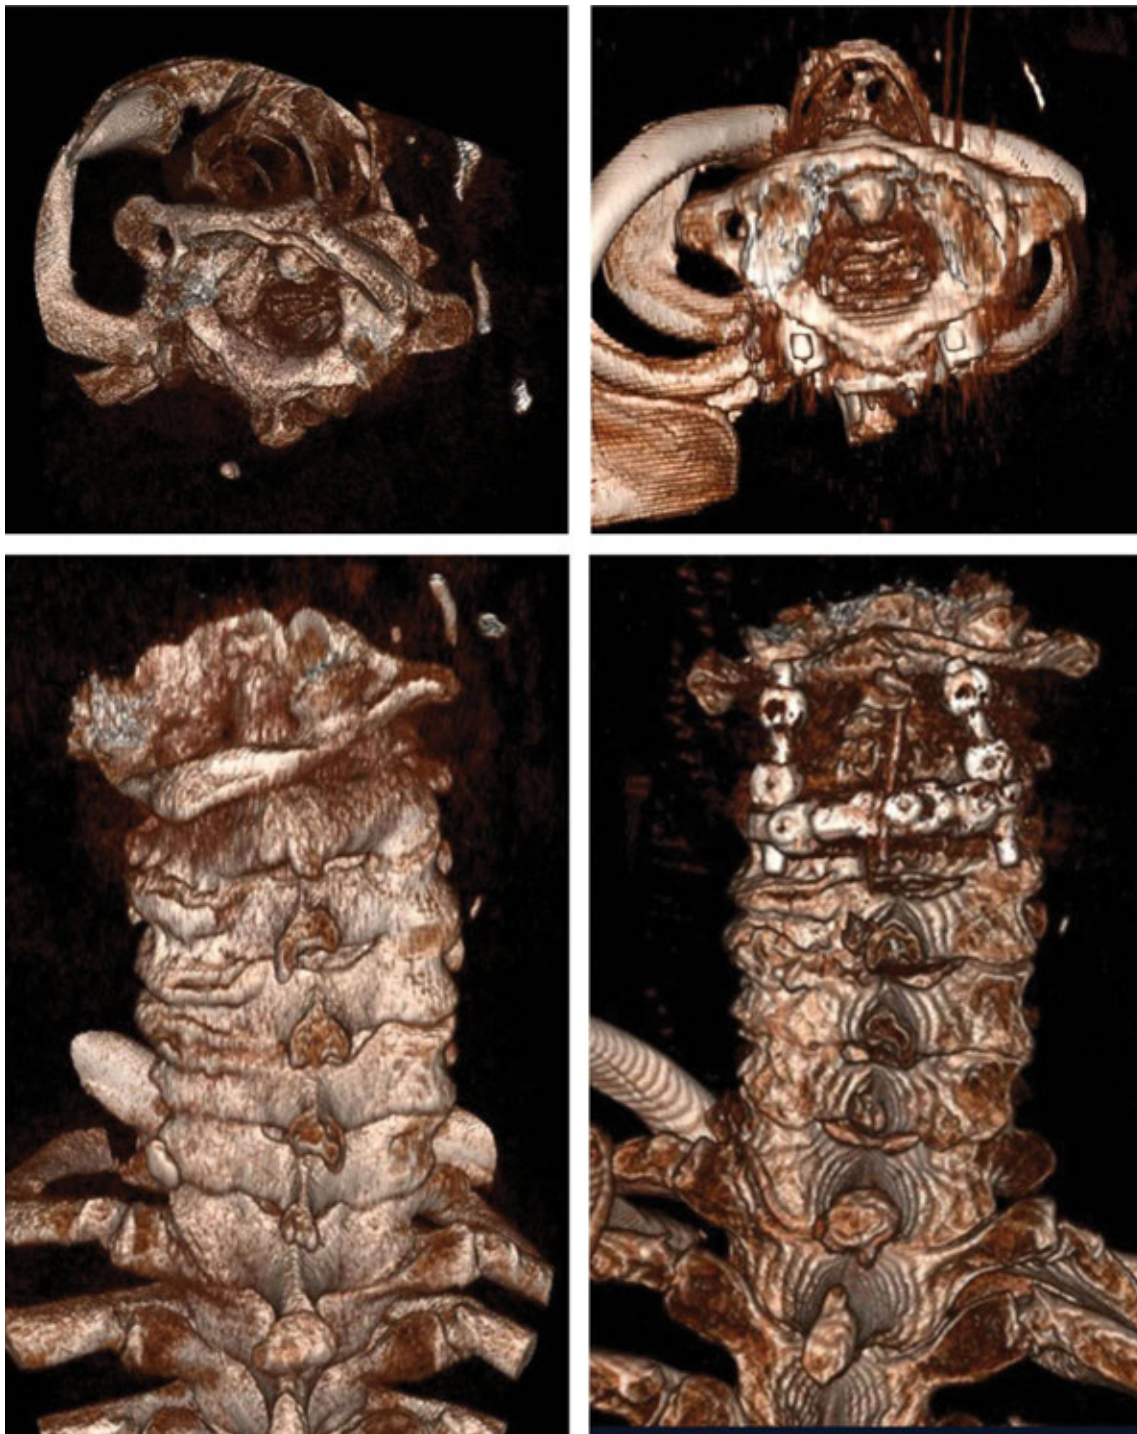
3D CT reconstructions demonstrating interval reduction of C1-C2 rotatory subluxation (LEFT: Pre-Operative; RIGHT: Post-Operative).
